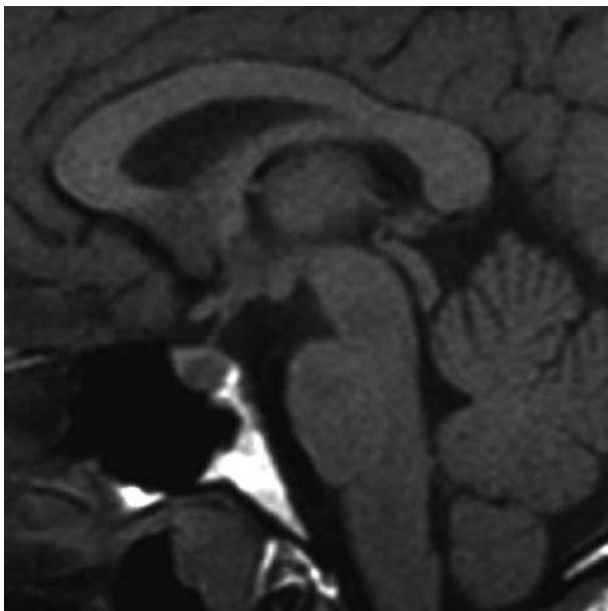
Magnetic resonance image (MRI) of a microprolactinoma.
